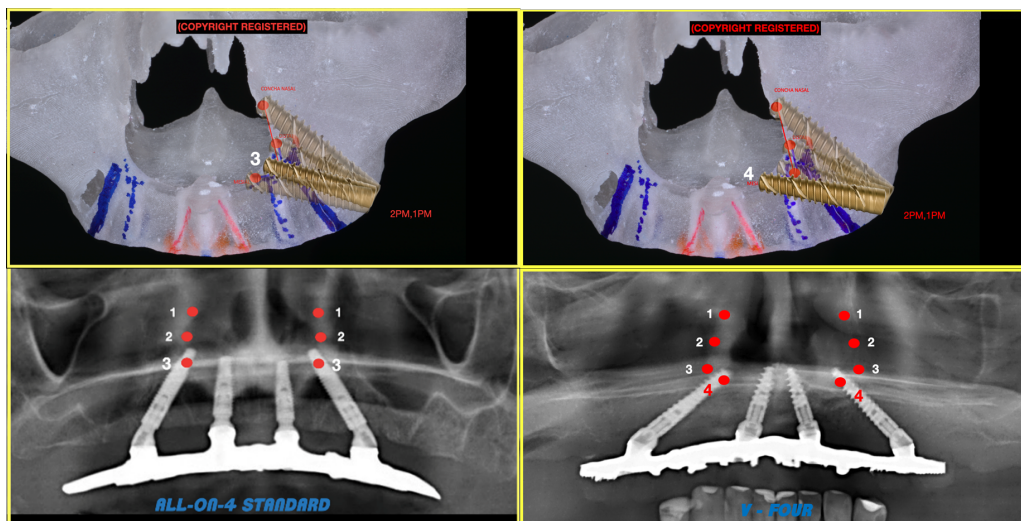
Arrangement of points 3 and 4 in the surgical planning and on the x-ray
